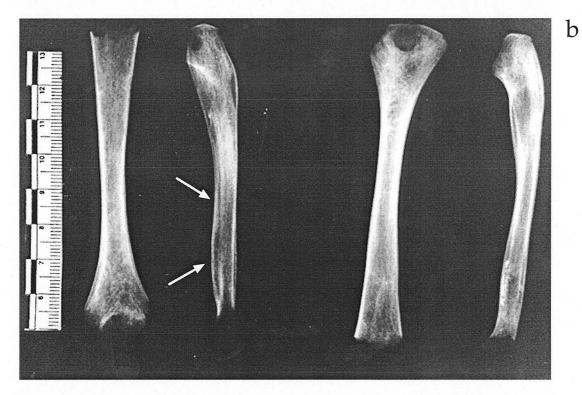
a; Active grade OB1 of ulnae of a subadult. The subperiosteal new bone has formed on the distal and proximal ends of the bone (arrows). b; A radiograph of the ulnae and humerus of the same individual. The subperiosteal new bone is seen as a shell encasing the original cortical margin (arrow)
